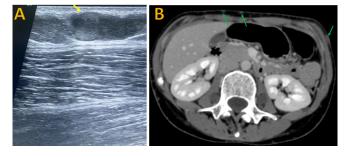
The ultrasound of the forehead shows a well-defined, lobulated, outlined, elongated hypoechoic mass lesion involving the subcutaneous tissue (yellow arrow). B) axial contrast-enhanced computed tomography scan section at the upper abdomen shows a few small subcutaneous enhancing fibromas (green arrows).
